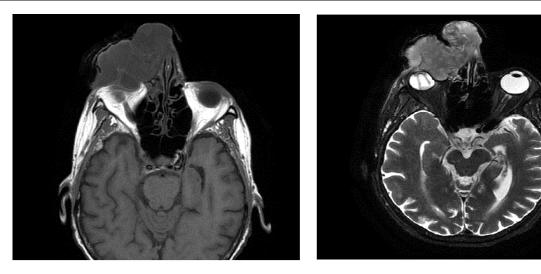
MRI shows a left orbital mass (left) transaxial T1 weighted MRI image demonstrates an 8 cm mass that is hypointense relative to cerebral cortex with peripheral contrast enhancement. (Right) transaxial T2-weighted MRI the mass is isointense relative to cerebral cortex.
